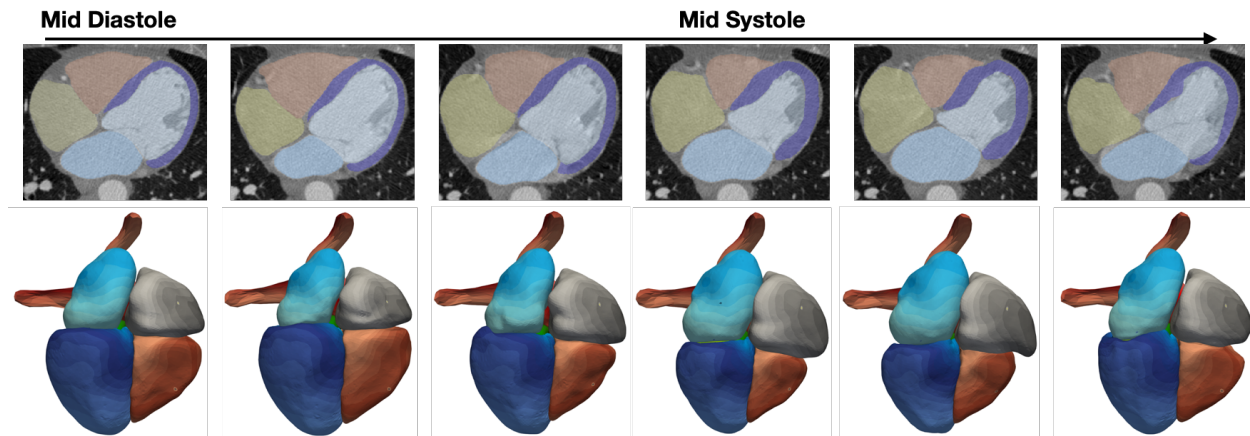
Whole-heart reconstruction results for time-series CT data. From left to right, each column displays results at one time frame from middle diastole to early diastole. The top row shows predicted segmentation overlaid with CT images and the bottom row shows the correspondence maps of mesh vertices across reconstructed meshes from different time frames, with same color denoting the same mesh vertices on reconstructed meshes.
